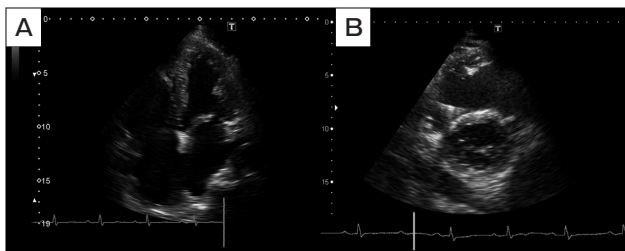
Apical four-chamber view (A) and short-axis view (B) showing the dilated right ventricle.
